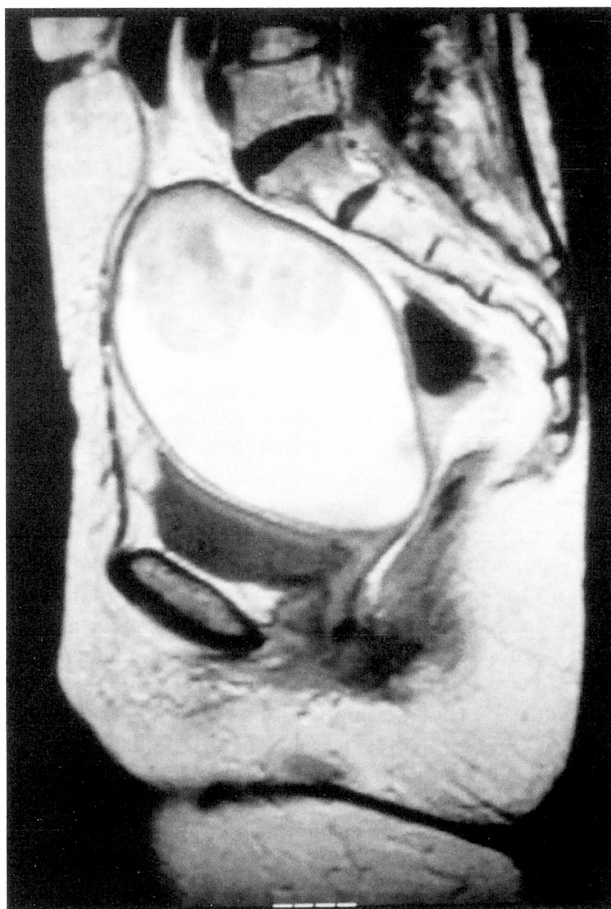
MR imaging of case 1 revealed an enlarged uterus and pyometra (T₁-weighted image).
